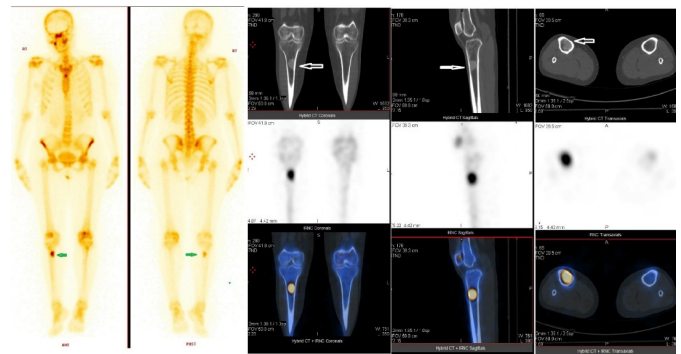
Tc-99m-MDP Whole Body Bone Scintigraphy and SPECT/CT shows there is increased radiotracer in the proximal shaft of right tibia likely metastases.
